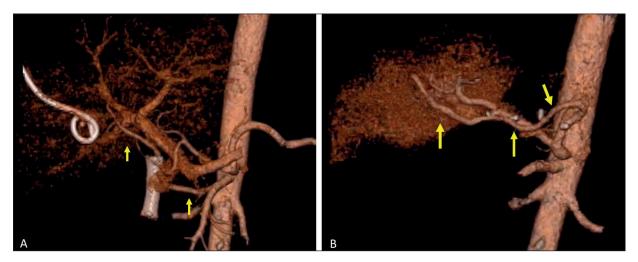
Pre-operative 3D Volume Rendering (VR) CT-scan (A) with yellow arrows indicating the RHA arising from SMA. Post-operative 3D VR CT-scan (B) showing the SA transposition for revascularization of RHA.
